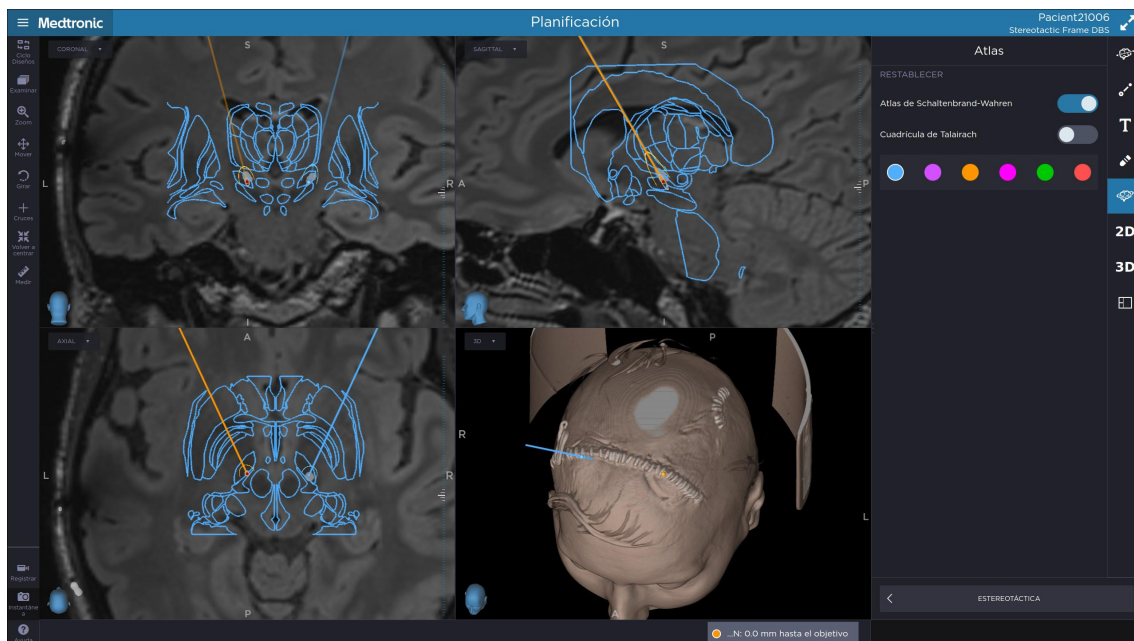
Schaltenbrand-Wahren Atlas overlaid with the coregistered image of MRI T2 and CT
